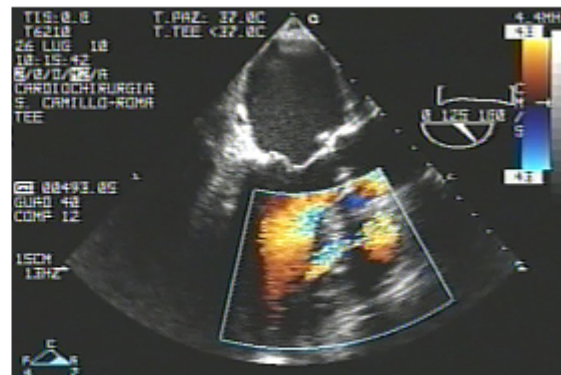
Intraoperative TEE: a clear left-to-right shunt was detected on color Doppler.
